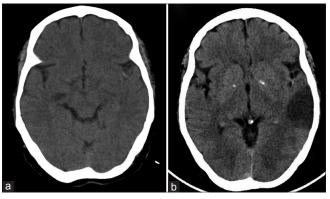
(a) Plain computed tomography brain after 3 h of stroke with hyperdense left middle cerebral artery. (b) 24 h computed tomography brain with evolved infarct and disappearance of hyperdense artery
